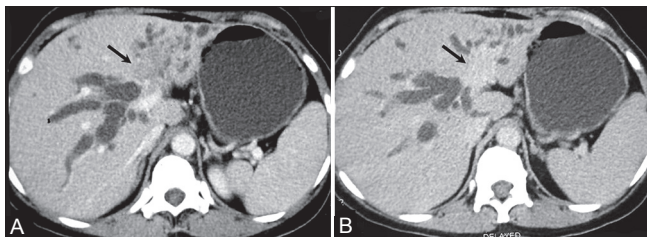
(A, B): Axial contrast-enhanced CT scan in venous (A) and delayed (B) phases showing hypodense mass lesion (arrow) involving primary biliary confluence and left hepatic duct with atrophy of left lobe of liver and involvement of portal vein. Note the delayed enhancement of the mass (B)
